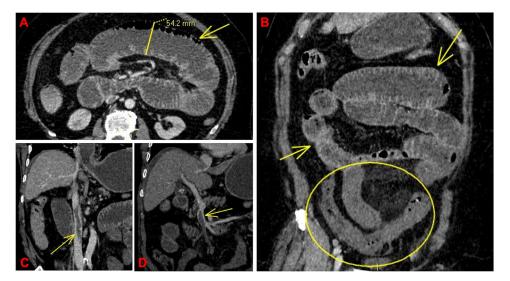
Images from portal venous phase CT scan of the abdomen. A: Axial CT image highlighting the jejunal overdistension (caliber of \sim 54 mm; normal range < 30 mm), with associated signs of intramural bowel gas (arrow) as per pneumatosis intestinalis. Non signs of pneumoperitoneum identified. B: Paracoronal CT image nicely demonstrating the differences between the hypoenhanced/unenhanced (circle) and the regularly enhanced (arrows) small bowel loops: these findings are clearly suggestive of small bowel ischemia. C: Paracoronal CT image showing the longitudinal extension of a thromboembolic defect into the lumen of the inferior vena cava (arrow). D: Paracoronal CT reconstruction along the vascular axis of the superior mesenteric vein which is largely occupied by an extensive thromboembolic defect (arrow); the superior mesenteric artery and its main branches were patent (not shown).
